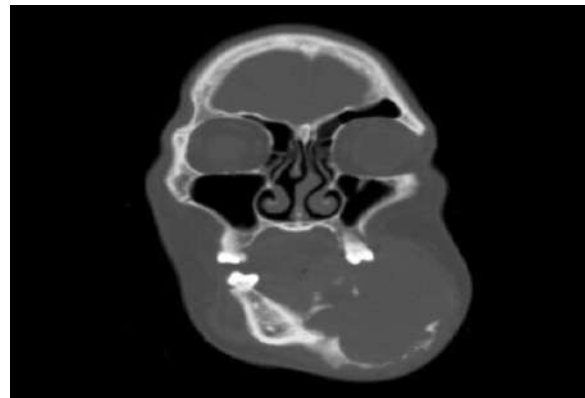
Coronal CT Scan examination
